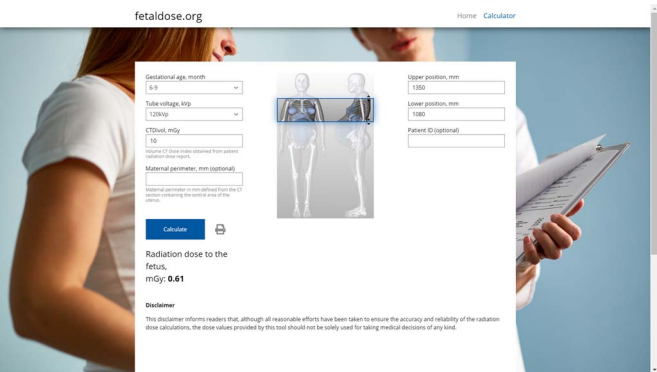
Graphical user interface of the web page for calculating fetal doses showing the example of a pregnant patient undergoing chest CT.
